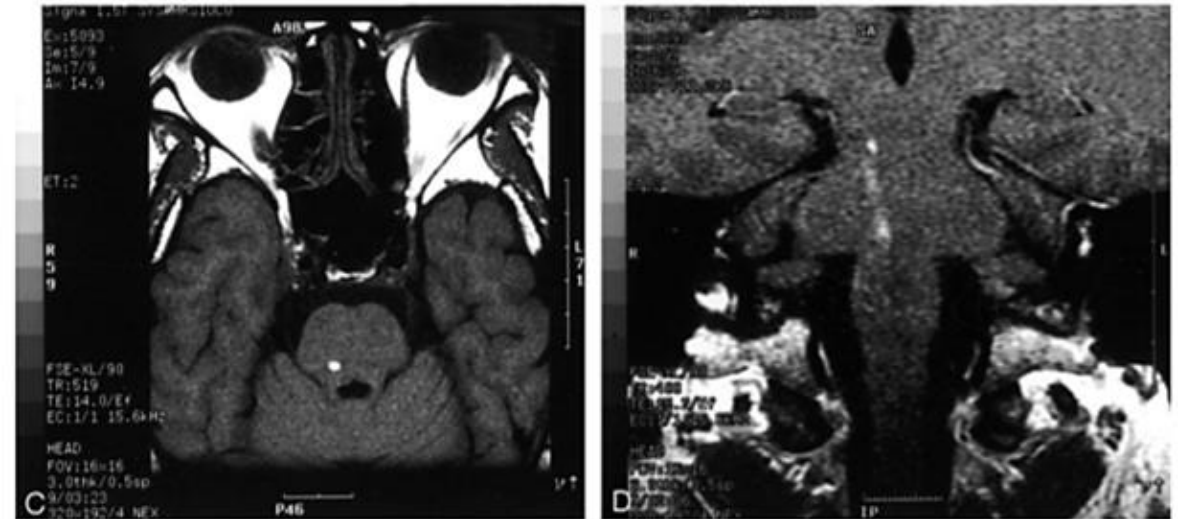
Case 1. MR images of spinal cord and brain.
